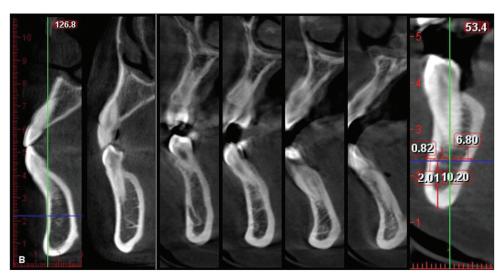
Para-sagittal sections of CBCT to detect MIC
